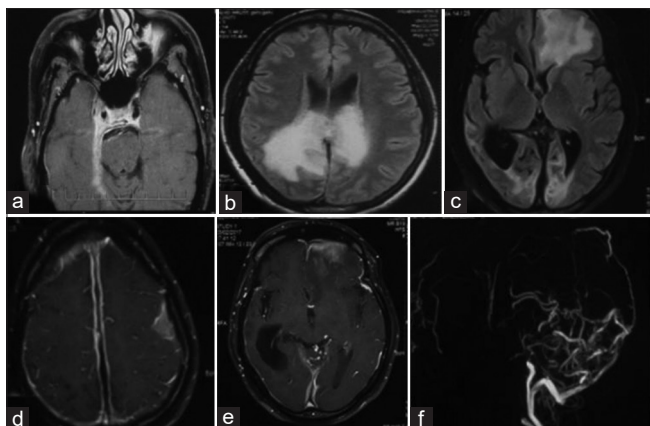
(a) Contrast-enhanced magnetic resonance imaging of the patient with right-sided ophthalmoplegia showing enhancement along the cavernous sinus and along the tentorium cerebelli (Patient 1). (b and c) Magnetic resonance imaging fluid-attenuated inversion recovery sequence showing tumor-like masses along the splenium and bilateral occipital lobes and left frontal lobe. (d and e) Magnetic resonance imaging T1-weighted images after gadolinium contrast showing enhancement along falx cerebri and cerebelli with cerebrospinal fluid loculated in between. (f) Magnetic resonance venography showing nonvisualization of the superior sagittal sinus suggesting obliterative phlebitis and organized collaterals (Patient 3)
